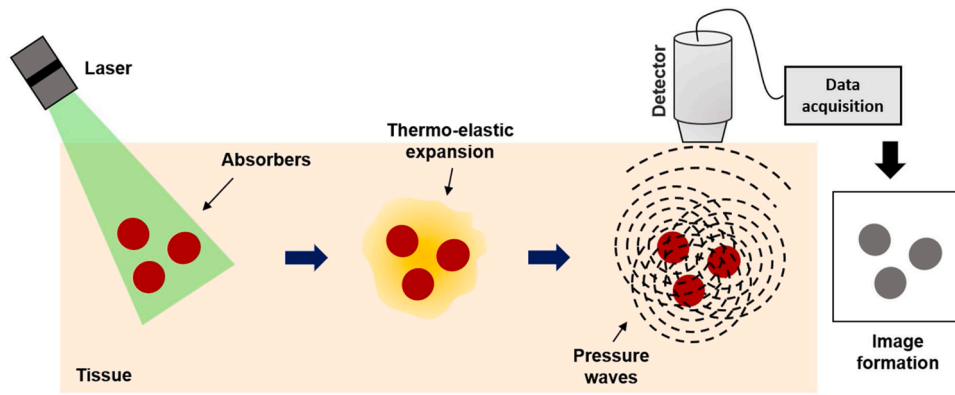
General principle of photoacoustic imaging. Targeted chromophores absorb optical energy resulting in a local temperature rise, inducing local pressure rise, which propagates outwards towards an ultrasonic transducer. The recorded signal is reconstructed to map the original optical energy deposition inside the tissue.
